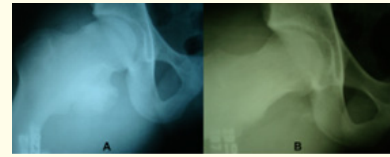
Patient with cam femoroacetabular impingement in right hip associated with osteochondroma in the femoral neck. (A) Preoperative radiograph of right hip in Dunn view at 45° with an alpha angle of 82° and (B) postoperative radiograph in the same view after femoral osteoplasty performed through anterior mini-open approach and tumor resection through medial access, at an alpha angle of 46°.
